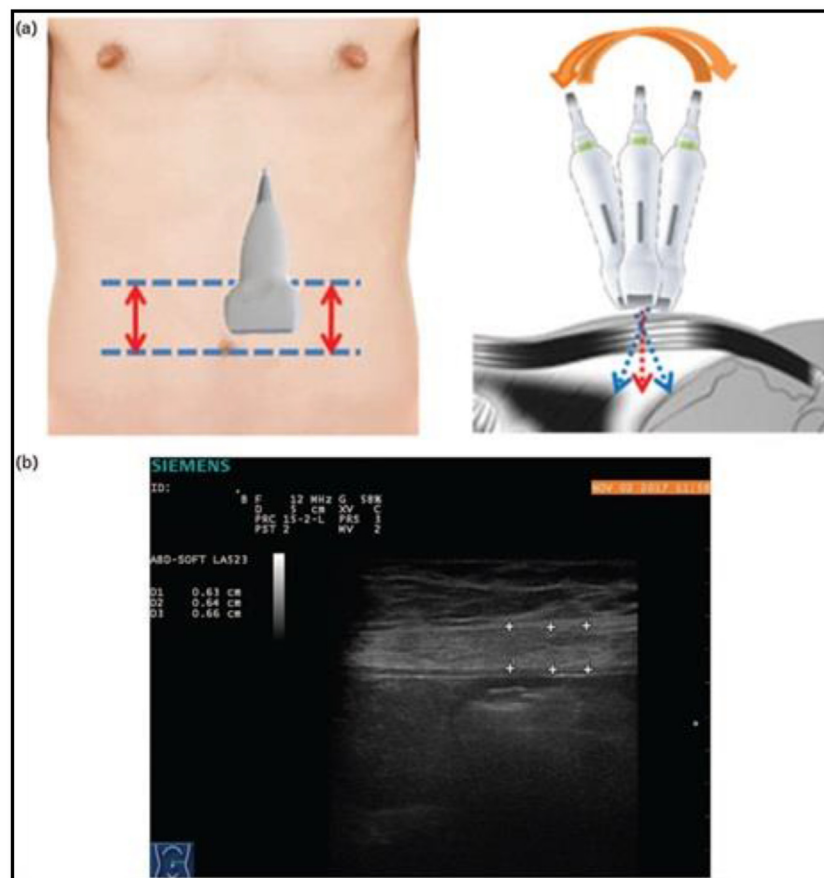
Measurement of rectus abdominis thickness by ultrasound.
